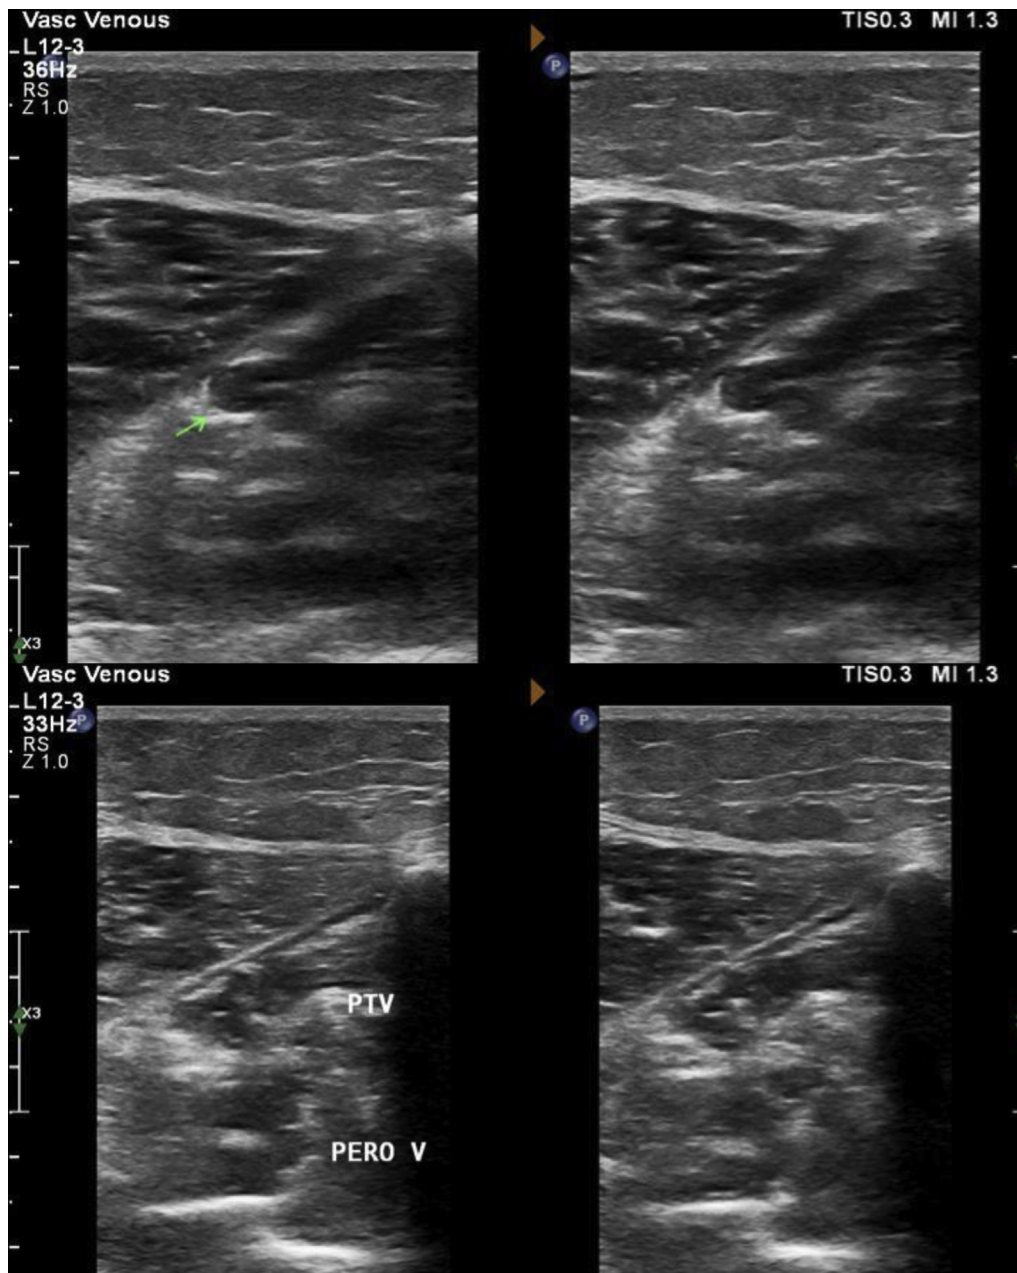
Dual screen ultrasound B-mode images of the tibial and calf veins were captured, with the right-side image demonstrating active compression. Noncompressibility of calf and tibial veins is suggestive of deep venous thrombosis (DVT).
